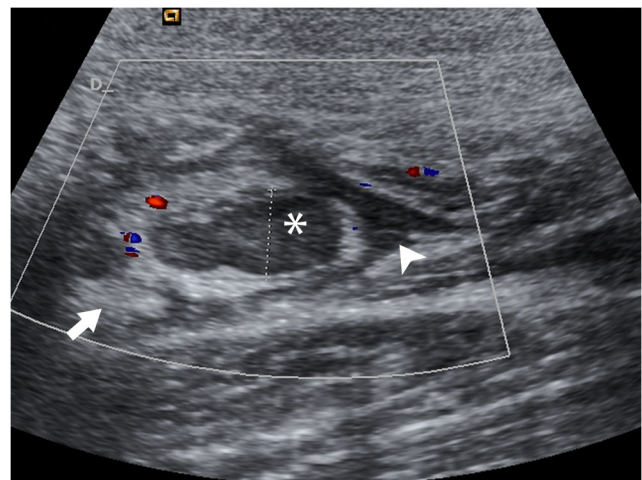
Familial Mediterranean fever in a 6-year-old girl with fever and abdominal pain. Transverse abdominal sonogram of the abdomen shows lymphadenopathy (asterisk), as well as thickening, hyperechogenicity and hyperemia of the mesentery (arrow), associated with a small amount of free fluid (arrowhead). In this setting, differential diagnosis includes other causes of acute abdomen, such as acute appendicitis
